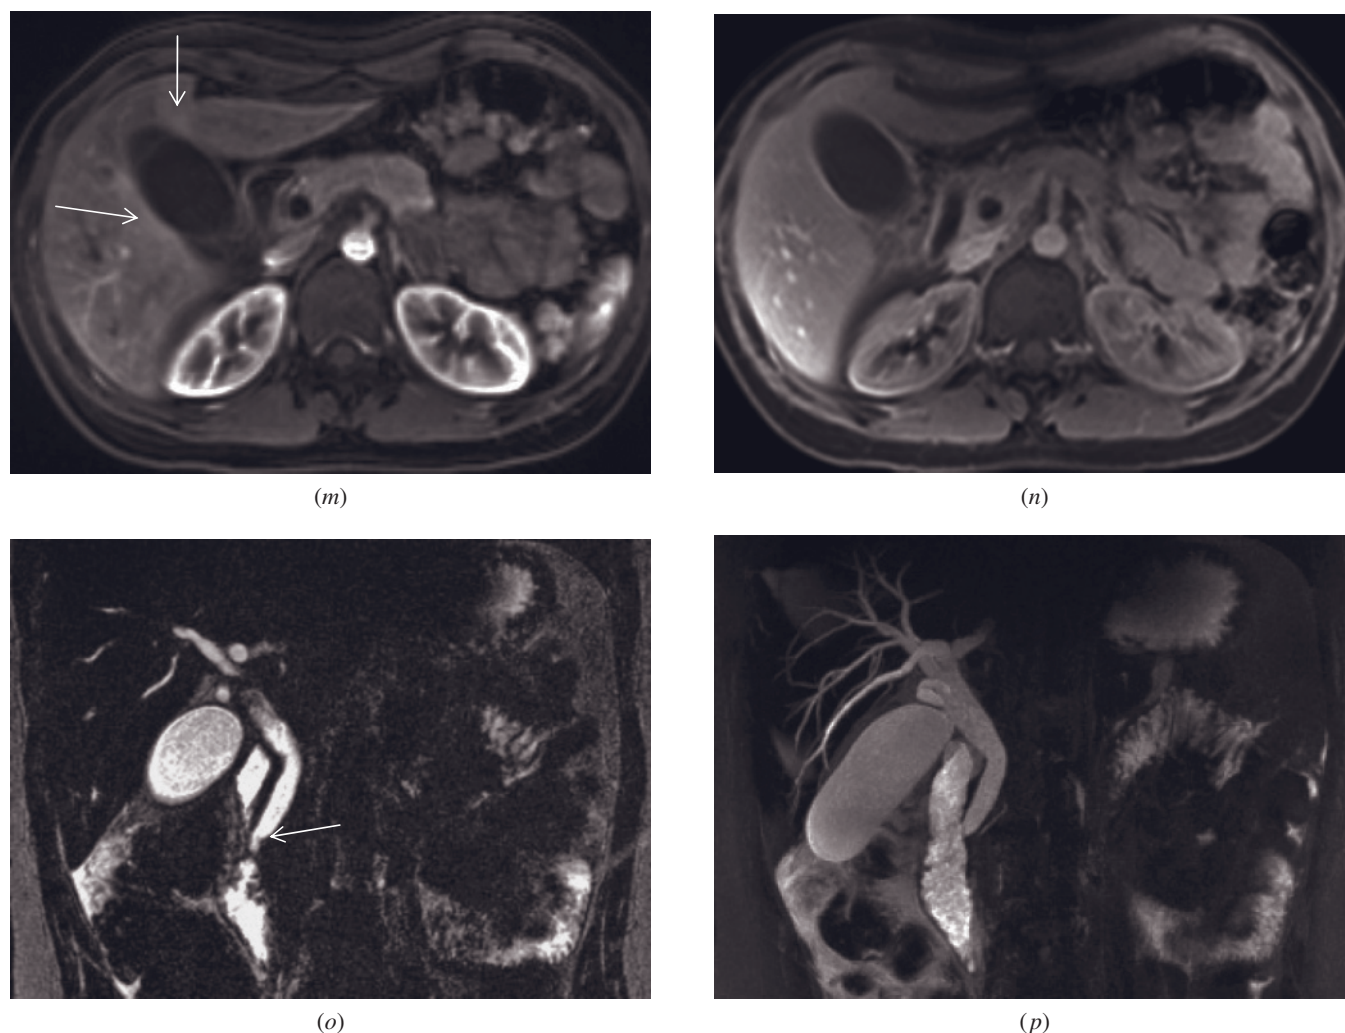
(Continued) the bile shows layering on T2-weighted image (*i*) and the gallbladder is enlarged. T1-weighted postgadolinium fat-suppressed 3D-GE (*m*, *n*) and T2-weighted thin section fast spin echo MRCP (*o*) and reconstructed 3D MIP MRCP (*p*) images at 3.0T demonstrate mild acalculous cholecystitis in another patient. There is transient increased pericholecystic hepatic parenchymal enhancement (arrows, *m*) on the hepatic arterial dominant phase (*m*), which fades to isointensity with the remaining liver parenchyma on the hepatic venous phase (*n*). The gallbladder wall shows prominent enhancement on the hepatic venous phase (*n*). MRCP images show the dilated biliary system due to ampullary stenosis secondary to passed stone. Fusiform ending of the common bile duct (arrow, *o*) suggests the presence of ampullary stenosis. Note that the gallbladder is enlarged.
